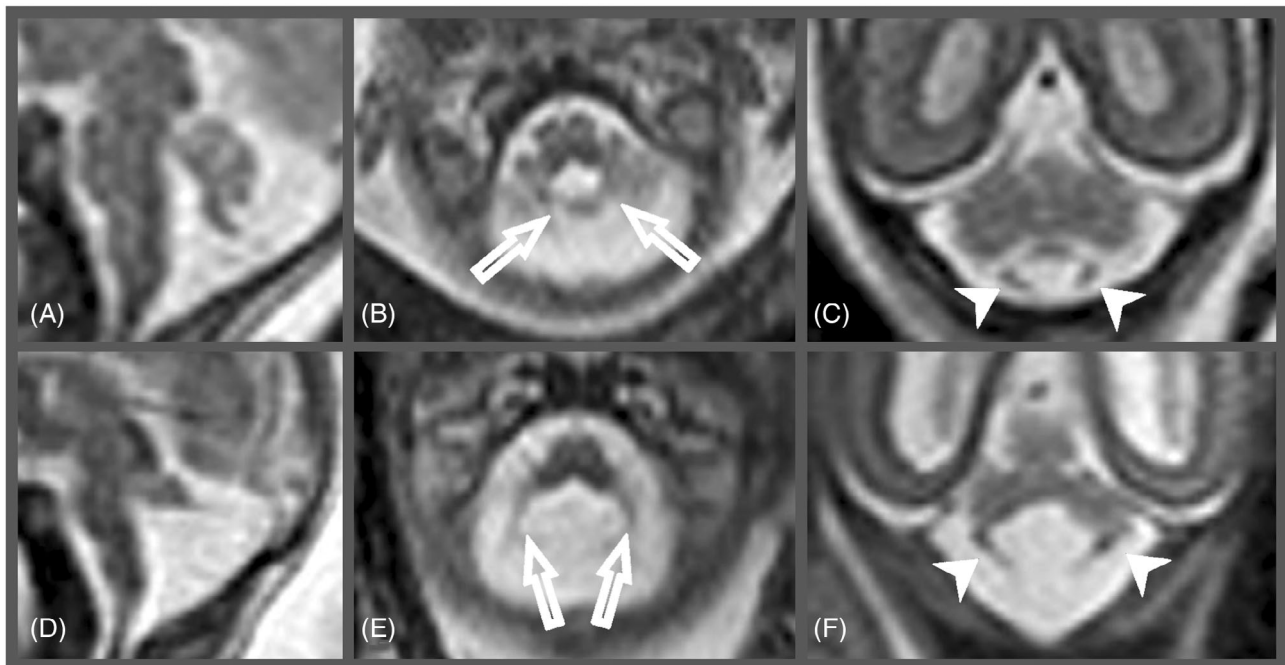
The taenia-tela choroidea complex in posterior fossa abnormalities. (A–C) Blake's pouch cyst at 21 GW. (A) sagittal T2-weighted image shows rotated vermis and cerebellar tail sign; (B) axial and (C) coronal T2-weighted images show median location of taenia-tela choroidea complex that tends to connect to the inferior vermis (arrows, B) and fourth ventricular choroid plexus above the anterior and inferior vermian margin (arrowheads C). (D–F) Dandy-Walker malformation at 21 GW. (A) Sagittal T2-weighted images shows classical counter-clockwise rotation of a hypoplastic vermis, forming a 70° brainstem-vermis angle; (E) axial and (F) coronal T2-weighted images show taenia-tela choroidea complex is spread out deviating from the midline and the vermis (arrows, E), as well as inferolateral location of the choroid plexus along the wall of the fourth ventricle (arrowheads, F)
